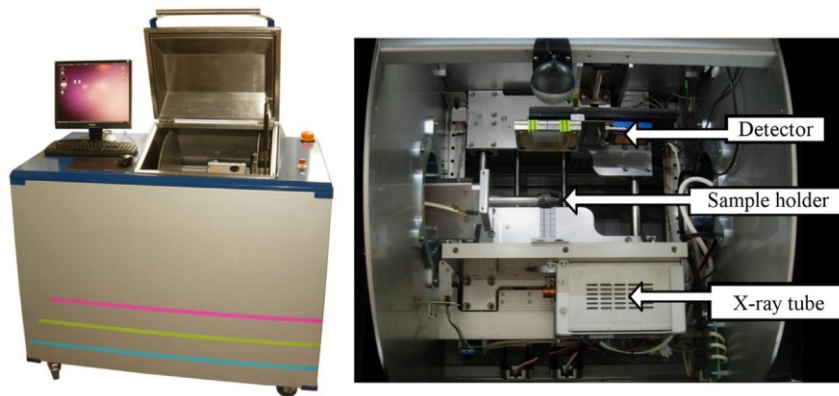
Redesigned MARS CT scanner with opened gantry (left), detailed view of the gantry with the new micro-focus X-ray tube KEVEXTM PXS-11 and the Timepix Quad detector newly installed (right).
